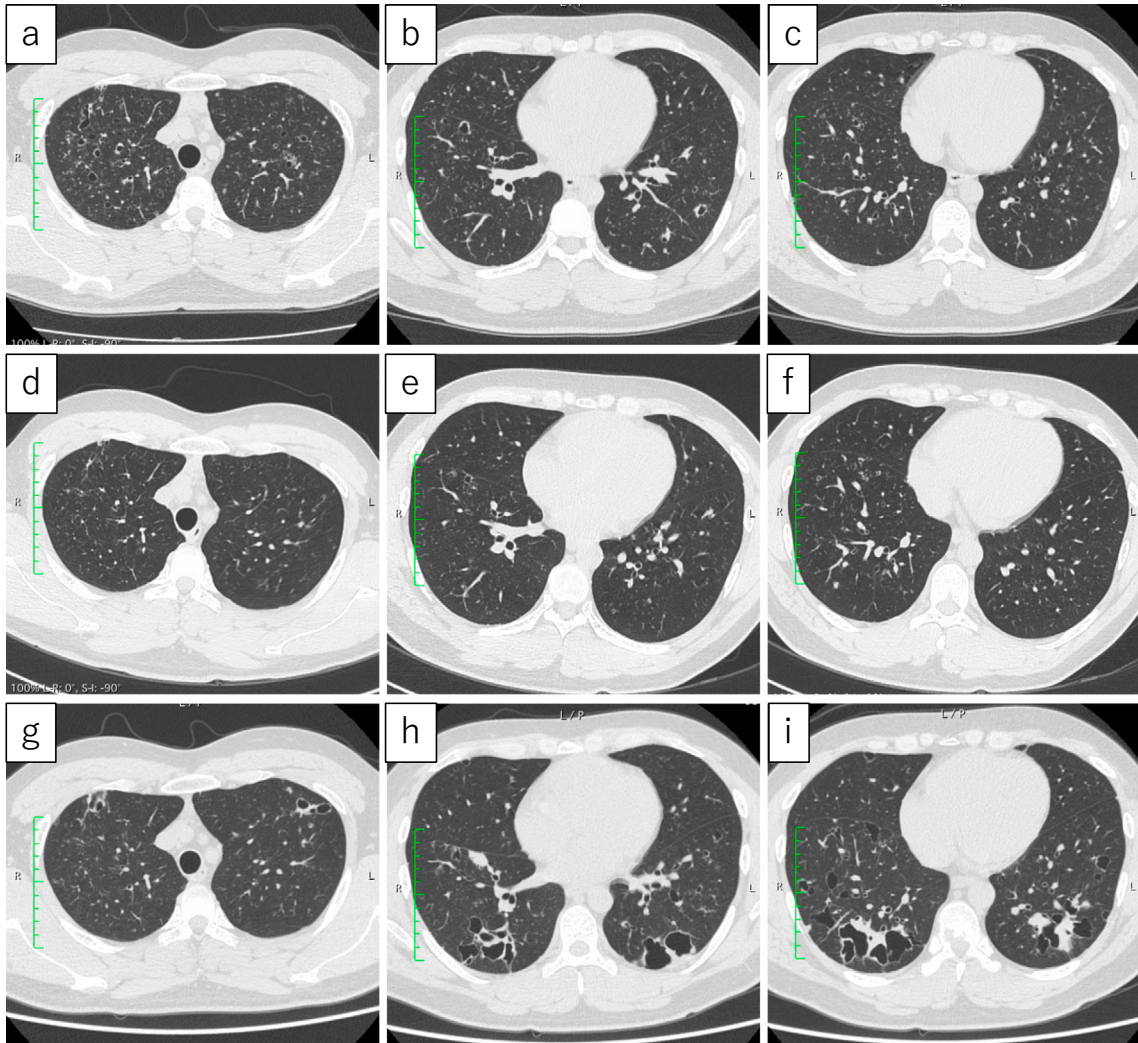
High-resolution computed tomography images of the chest at different time points. Randomly distributed fine granular and micronodular shadows were observed three years before the onset of symptoms, mainly in the upper lobe. An irregular, small, cavernous shadow had been observed, and part of the cavity wall was thickened (a-c). Both the granular and cavernous shadows had disappeared after a year (d-f). At the time of the diagnosis, the lower lobe predominantly showed numerous cavernous lesions resembling fused cysts. The cavity walls were mostly thin; however, some walls were thickened and show nodular shadows (g-i).
